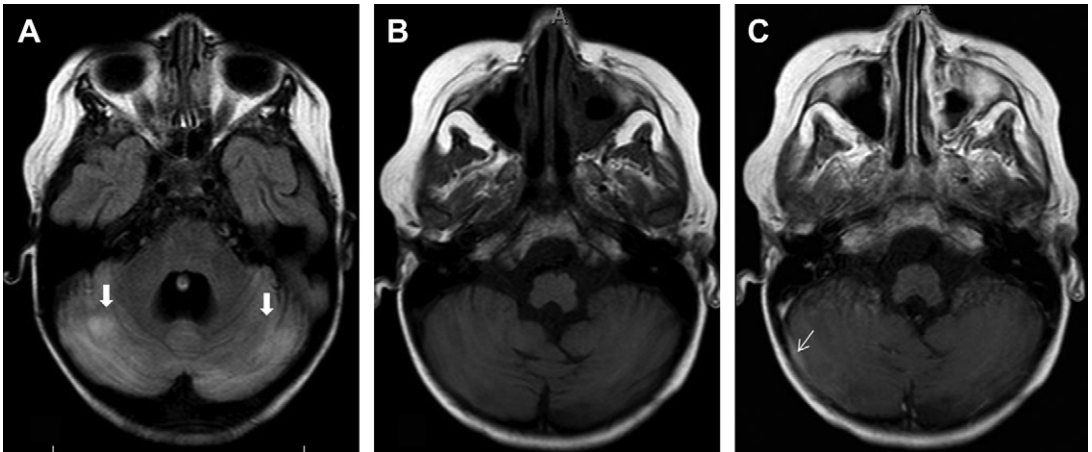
Acute cerebellitis in a 9-year-old boy. Axial FLAIR imaging (A), plain axial T1WI (B) and contrast-enhanced axial T1WI (C) show diffuse hyperintense signal in bilateral cerebellar hemispheres (*white block arrows*), with some volume loss and increased leptomeningeal enhancement (*white arrow*), especially overlying the right cerebellar hemisphere.
